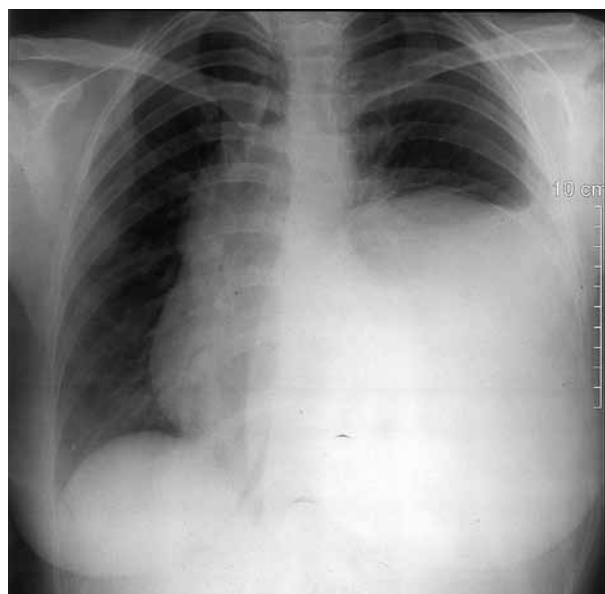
X-ray showed large mass in the left lower zone.
